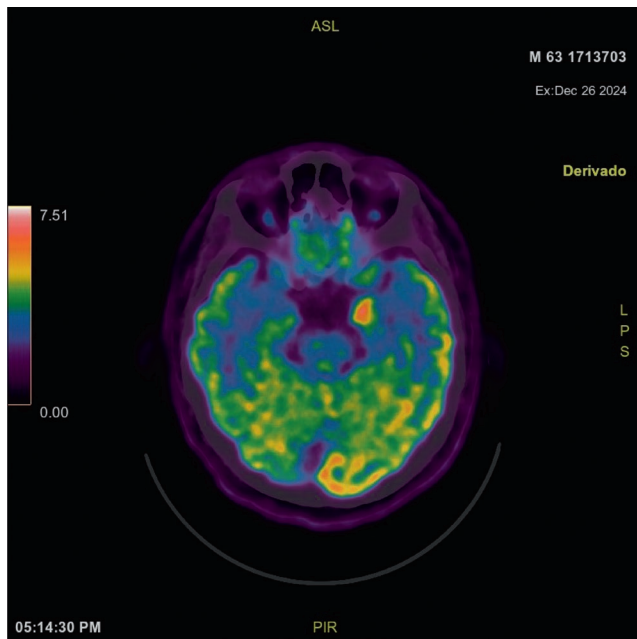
Brain PET/CT scan revealing enhancement in the medial area of the left temporal lobe.
